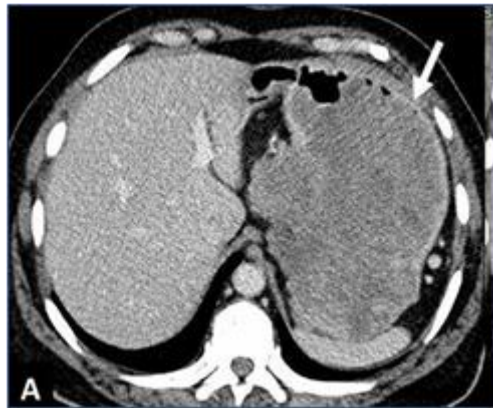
CT abdomen showing a large heterogeneously enhancing exophytic mass arising from the body of the stomach
